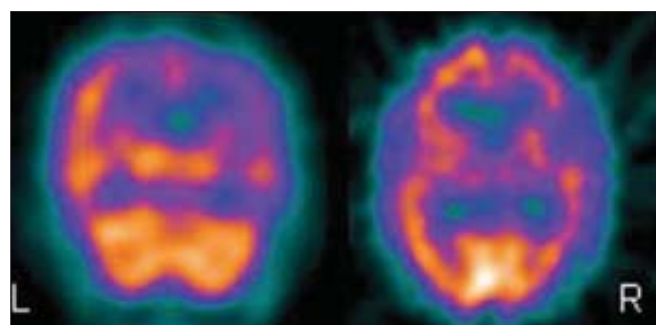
Axial SPECT image of the semantic dementia – Case 1 (left panel) and the progressive nonfluent aphasia patient – Case 2 (right panel) showing reduced perfusion in the left frontotemporal regions
